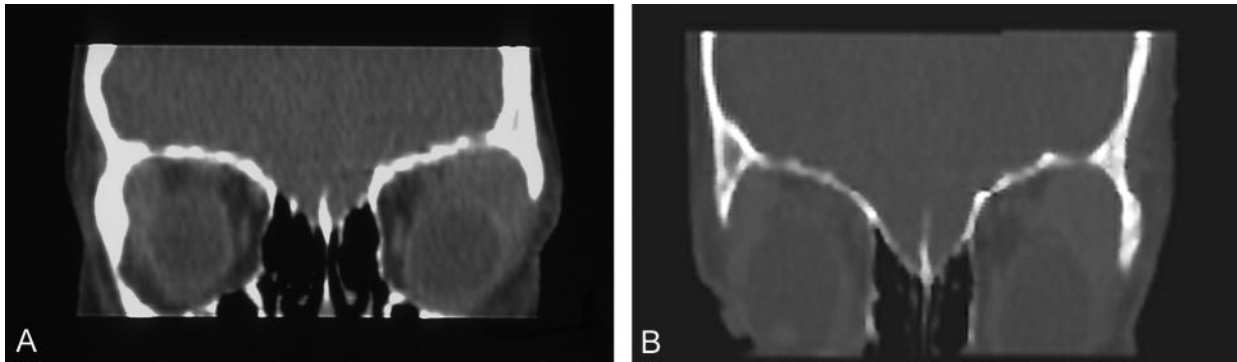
Coronal view CT reconstruction.
